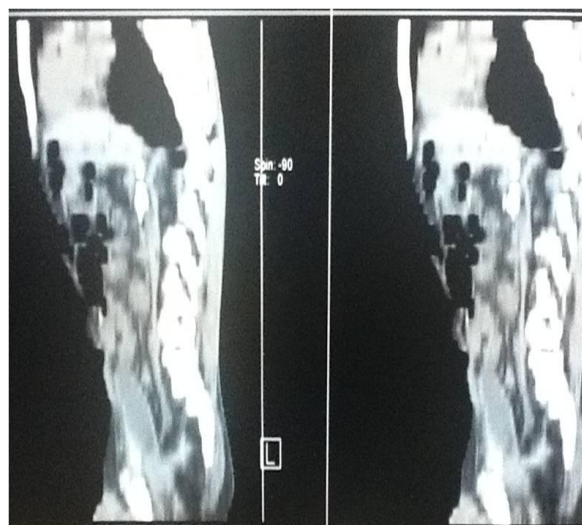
CT scan - Pancreatic calcification.
